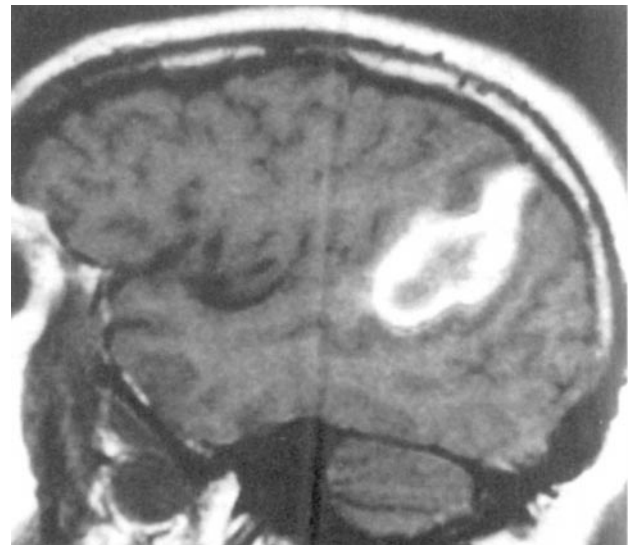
MRI sagittal T1W subacute intraparenchymal hematoma-hypersignal area
